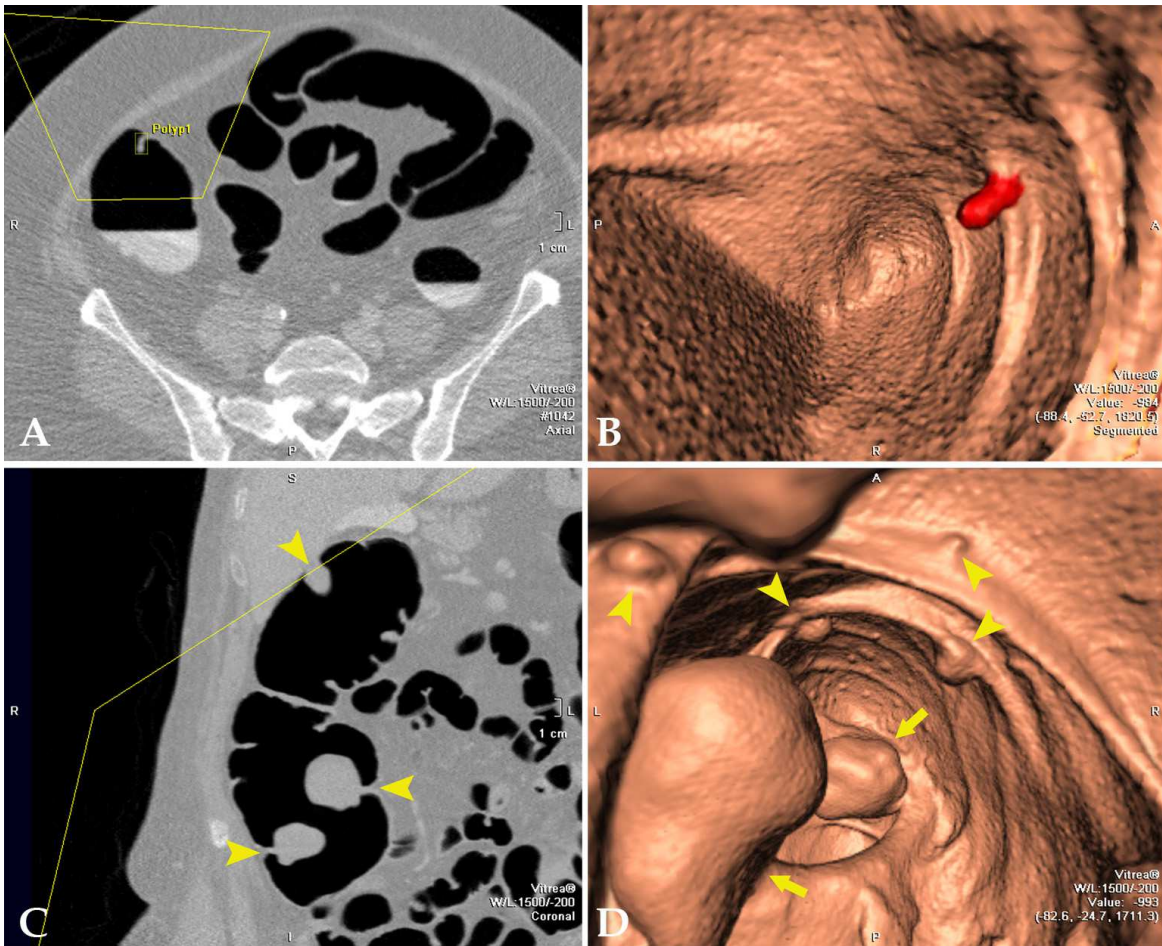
(A) The appearance of a stalked polyp of the ascending colon on 2D axial CT colonographic image. (B) Translucency rendering view shows a homogenous red bulging revealing the polyp. (C) The appearance of stalked polyps on 2D coronal CT colonographic image (arrowheads). (D) 3D CT colonographic image shows stalked (arrows) and sessile (arrowheads) polyps.
